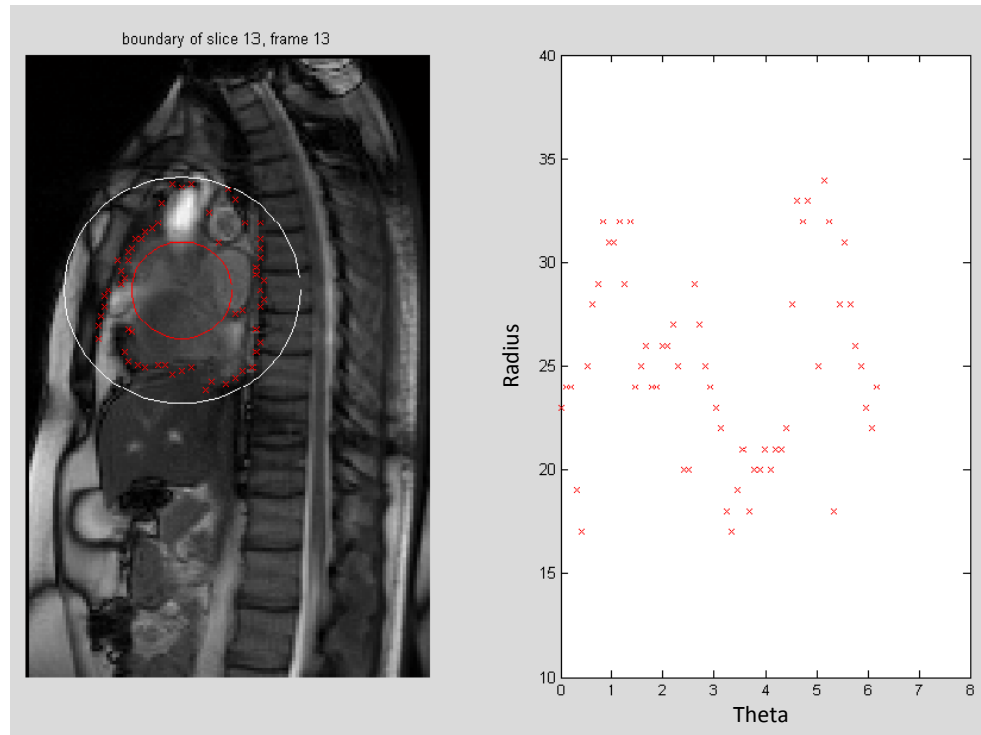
Points found in the 13th slice and 13th frame. In the left, on the real MRI.
